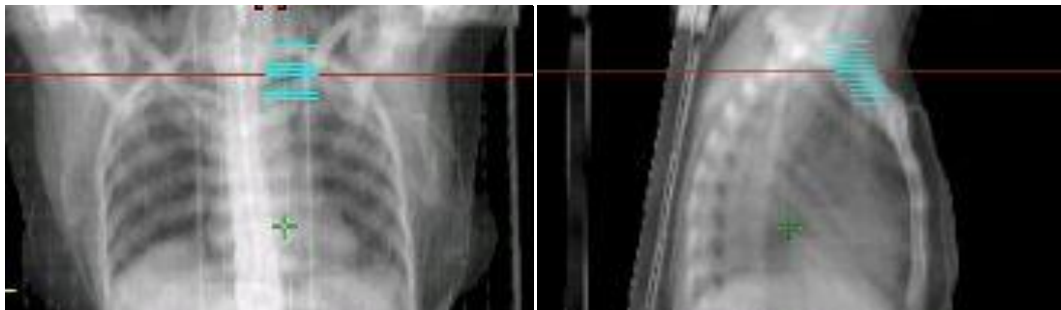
Digitally reconstructed radiographs showing PTV on coronal and sagittal views.
